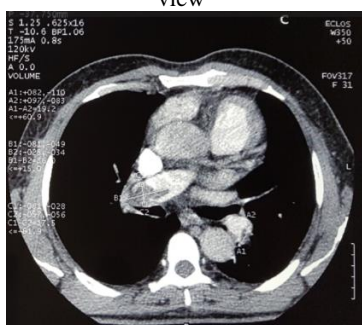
Thoracic CT angiogram showing truncular pulmonary embolus
